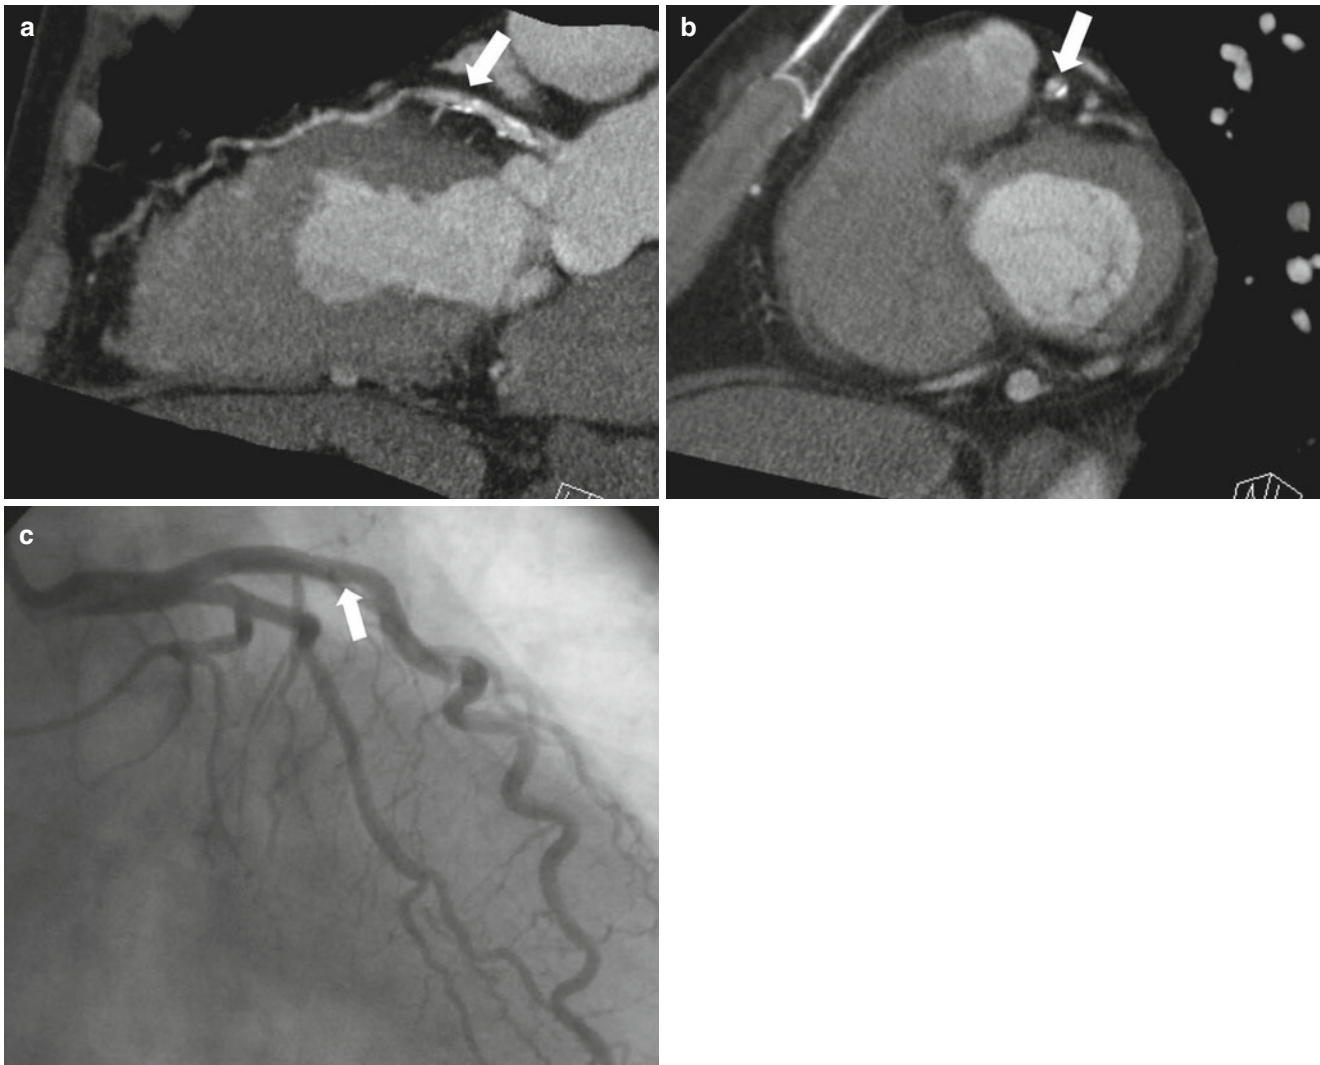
Moderate degree of atherosclerotic stenosis in mLAD on CTA with moderate amount of plaque burden on intravascular ultrasonography (IVUS). (a) B-MPR image of LAD on coronary CTA shows mixed plaque (arrow) in mLAD. (b) Short-axis (SA) image on coronary CTA shows moderate degree of luminal narrowing in mLAD (arrow) after adjustment of window width and level to minimize the blooming
